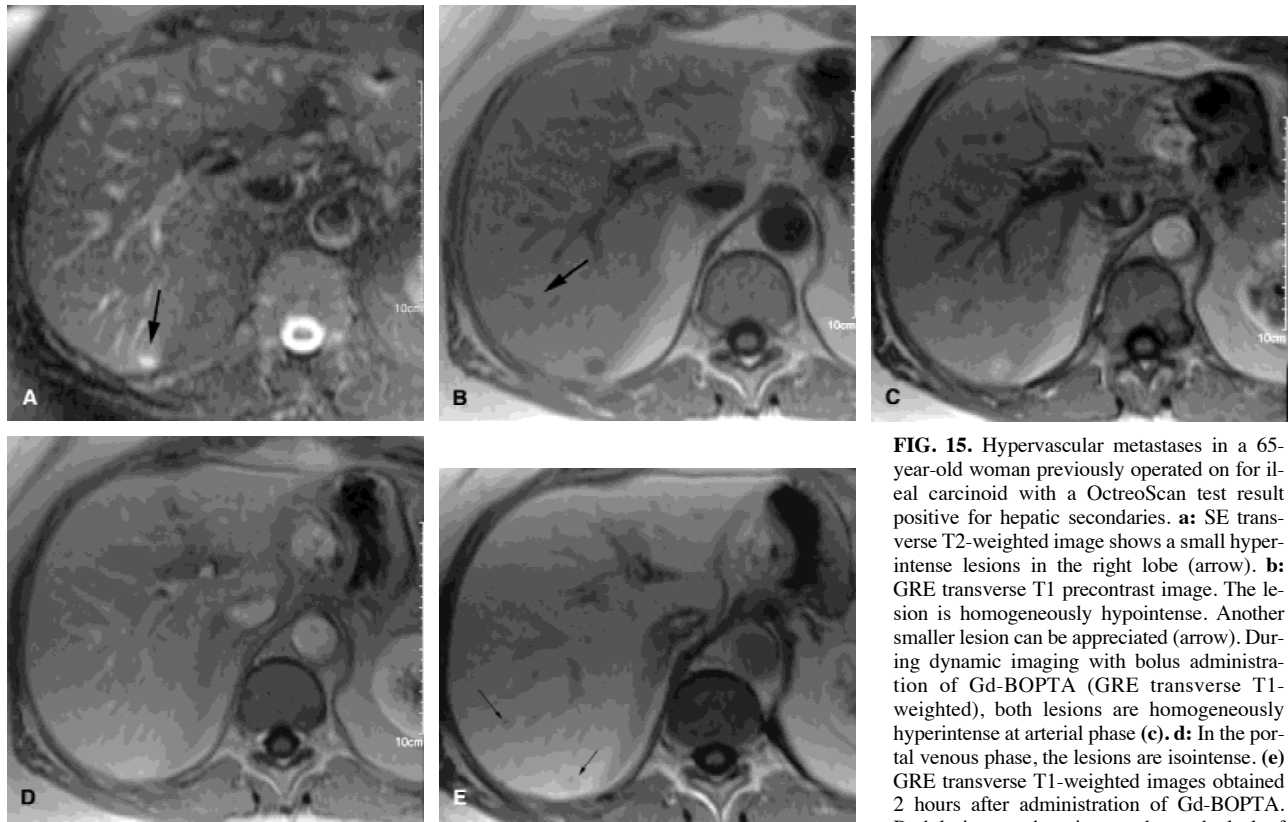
Hypervascular metastases in a 65-year-old woman previously operated on for ileal carcinoid with a OctreoScan test result positive for hepatic secondaries. a: SE transverse T2-weighted image shows a small hyperintense lesions in the right lobe (arrow). b: GRE transverse T1 precontrast image. The lesion is homogeneously hypointense. Another smaller lesion can be appreciated (arrow). During dynamic imaging with bolus administration of Gd-BOPTA (GRE transverse T1-weighted), both lesions are homogeneously hyperintense at arterial phase (c). d: In the portal venous phase, the lesions are isointense. (e) GRE transverse T1-weighted images obtained 2 hours after administration of Gd-BOPTA. Both lesions are hypointense due to the lack of contrast media uptake.
